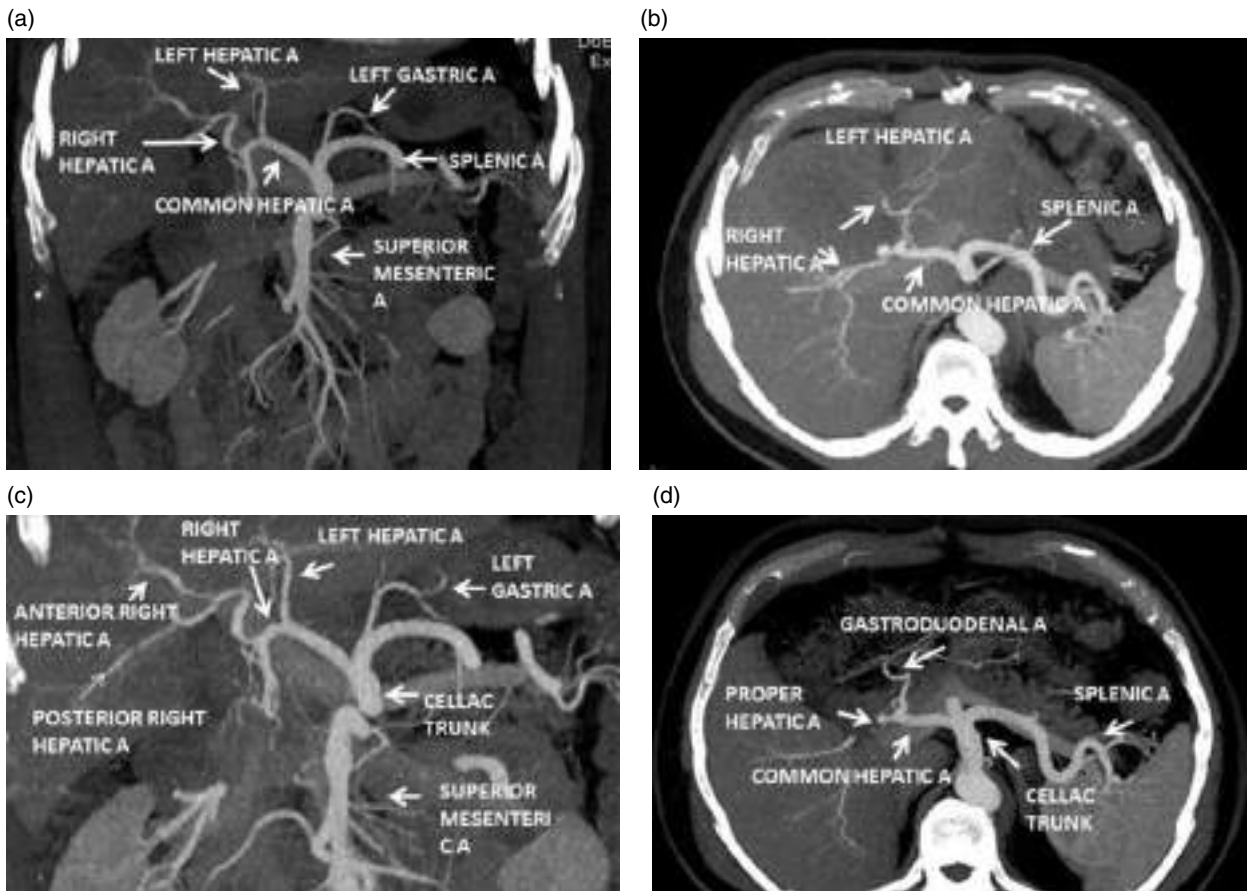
Celiac trunk and hepatic artery. (a, c) Coronal contrast-enhanced maximum intensity projection (MIP) CT image (arterial phase). (b, d) Axial contrast-enhanced maximum intensity projection (MIP) CT image (arterial phase).
